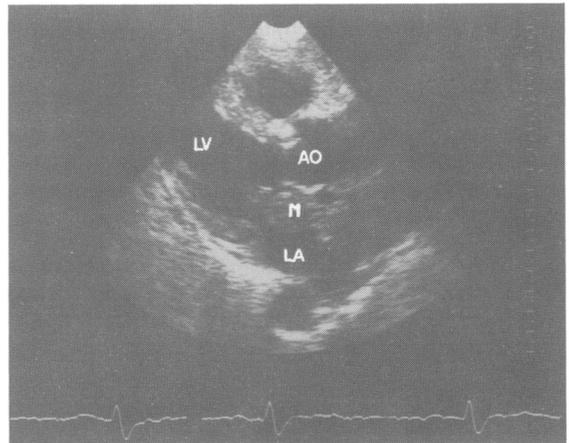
Cross-sectional echocardiography in parasternal long axis view showing the presence of a myxoma (M) in the left atrium (LA). LV, left ventricle; AO, aorta.
